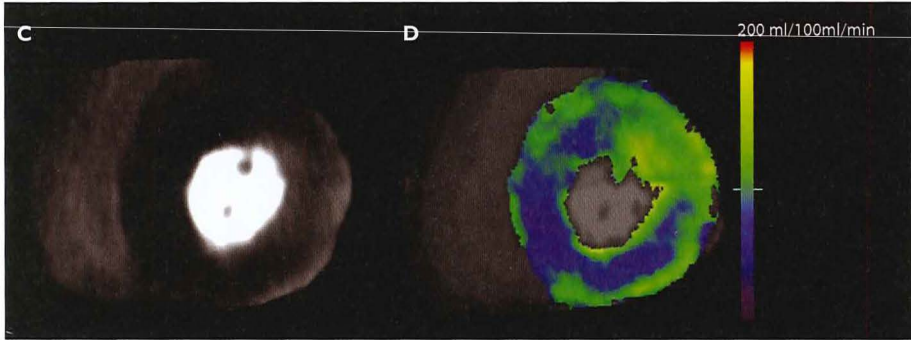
60-year-old man with typical angina. Curved multiplanar reformat images show extensive highly calcified plaques in the left anterior descending coronary artery, LAD, (A) and in the circumflex coronary artery, CX (B). Stress dynamic CT perfusion imaging, acquired using a dual source CT scanner, shows a perfusion defect in the anterior, antero-septal, infero-septal, and inferior myocardial wall (C) in a patient with left dominant coronary system. The color-code map (D) demonstrates substantially reduced myocardial perfusion in the anterior and antero-septal walls (86 ml/100ml/min) related to the LAD as well as the inferior and infero-septal wall (48 ml/100ml/min) related to the CX.
